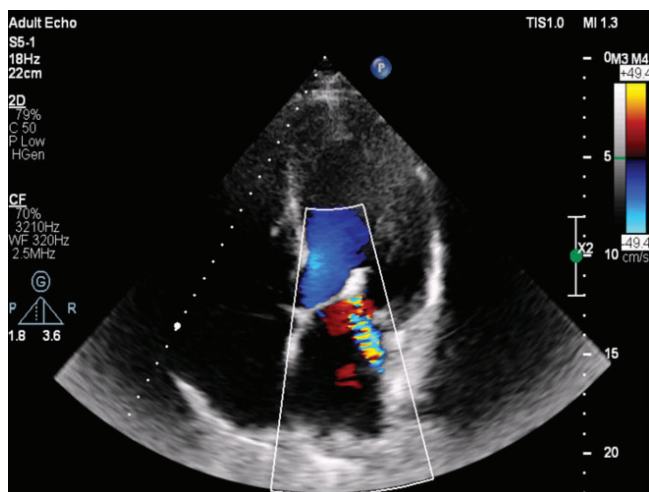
Apical four-chamber transthoracic echocardiographic view with color Doppler demonstrating mild (grade I+) mitral regurgitation at the five-month follow-up
